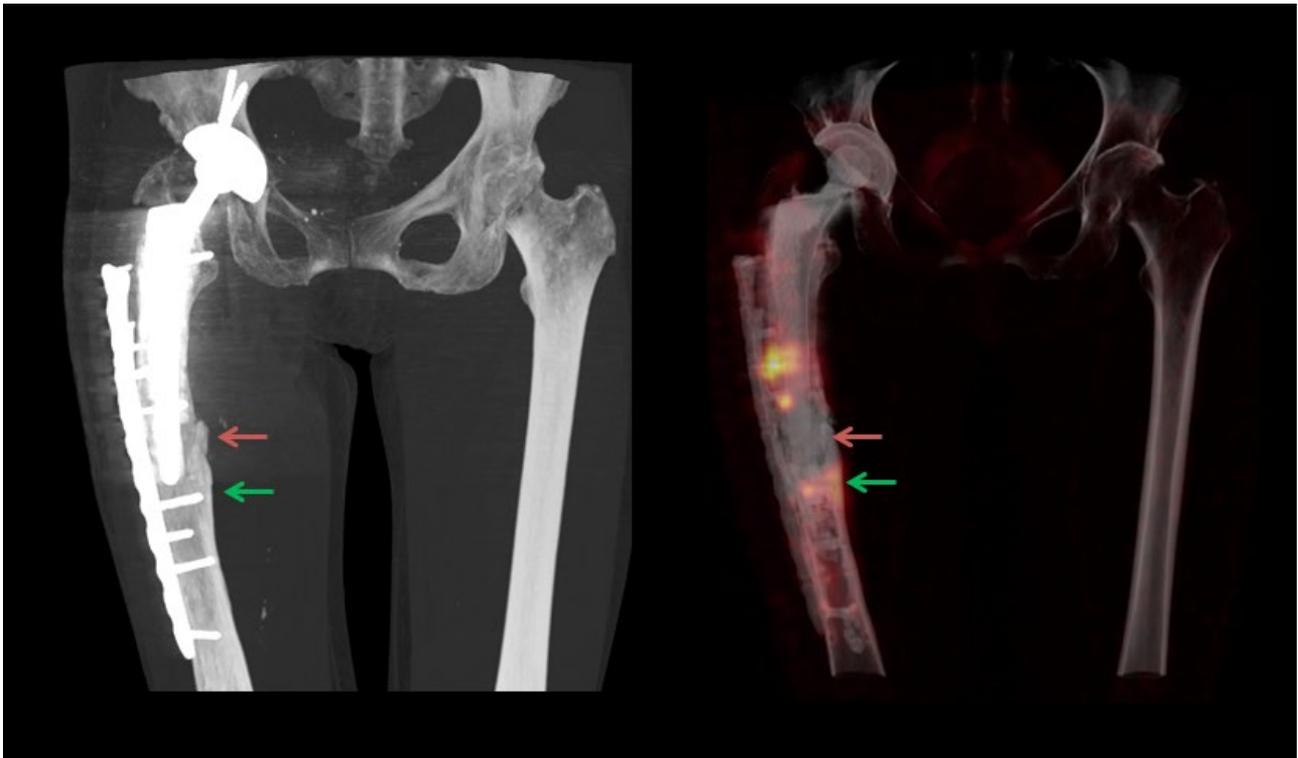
MIP of CT shows periprosthetic fracture (red arrow), which also corresponds to avascular area with absence of tracer uptake on the fused images (red arrow). The focal area of increased cortical uptake just below the fracture site (green arrow) reflects reactive hypermetabolism related to chronic pseudoarthrosis due to avascular bone segment just distal to the femoral component of the hip prosthesis. The acetabular component appears stable with no loosening or malalignment.
